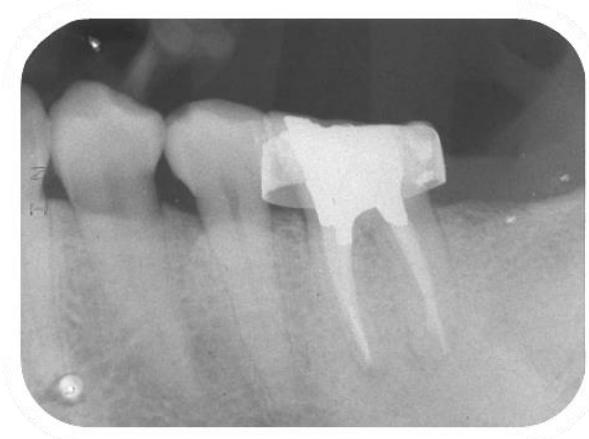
Intra-operative radiograph after removal of silver points
